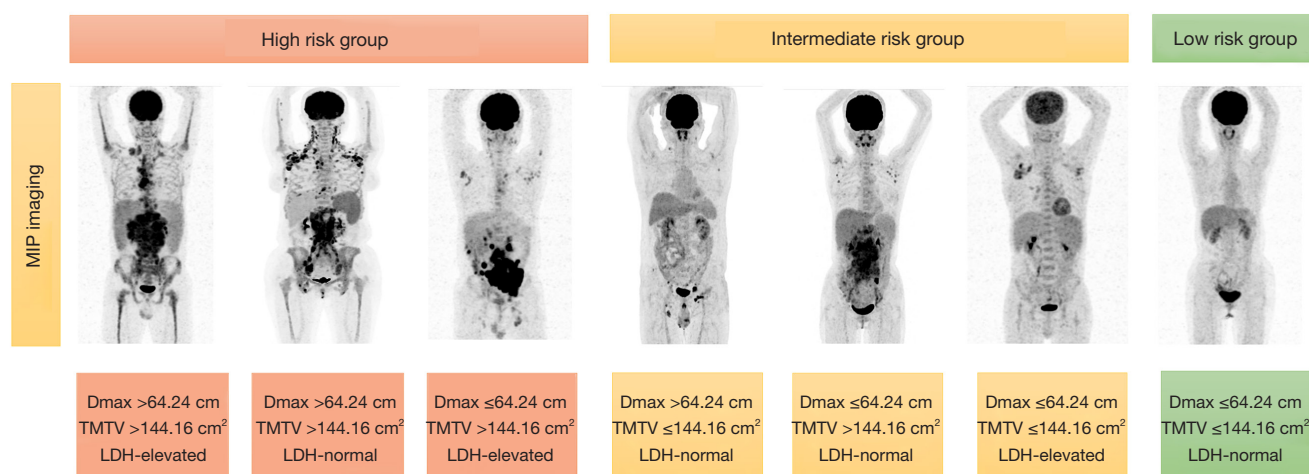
Demonstration of the present risk model using maximum intensity projection of fluorine-18-fluorodeoxyglucose PET/CT images. MIP, maximum intensity projection; Dmax, maximum tumor dissemination; TMTV, total metabolic tumor volume; LDH, lactate dehydrogenase; PET, positron emission tomography; CT, computed tomography.
